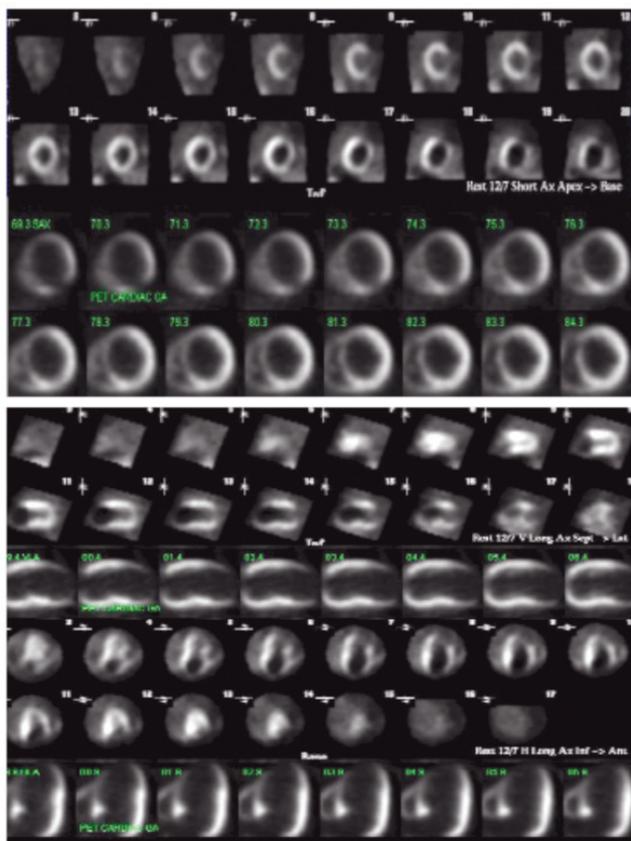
Multiplanar imaging of the myocardium using ^{99m}Tc MIBI in a 52 year old man known ischaemic cardiomyopathy. Stress MPI and rest FDG PET-CT demonstrate matching apical defects at segment 19 and 20 in keeping with infarction
